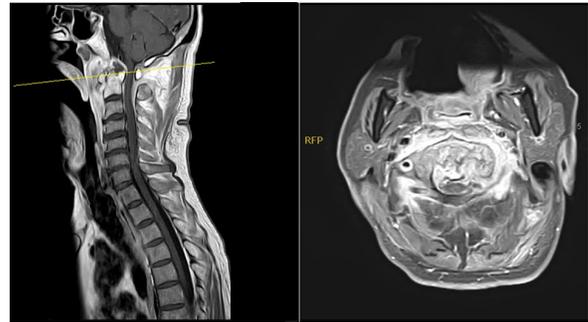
MRI revealed destructive lesion involving C1, C2 and left occipital condyle
